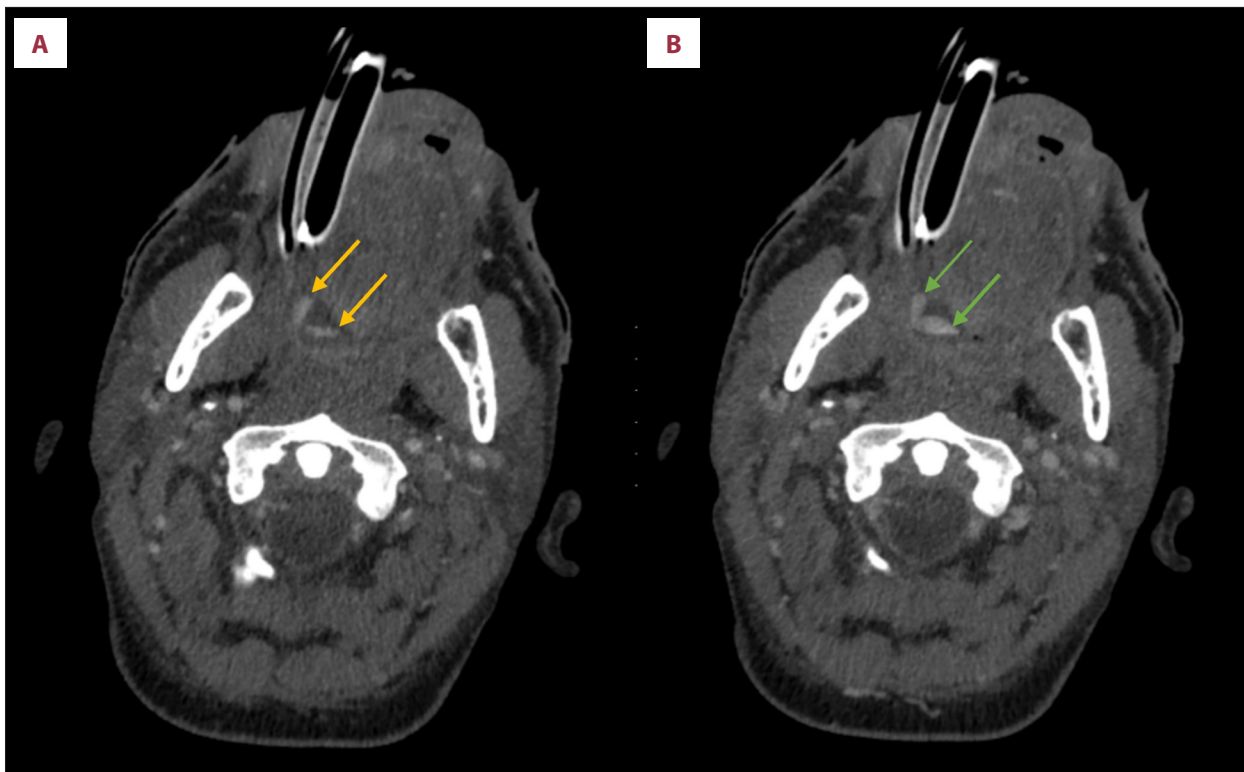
Oropharyngeal hemorrhage demonstrated on CTA head and neck. (A) Arterial phase, showing 2 foci of contrast blush involving the right lateral tongue (yellow arrows). (B) Portal venous phase, showing foci of contrast blush have expanded, suggesting active bleeding with venous pooling (green arrows).
